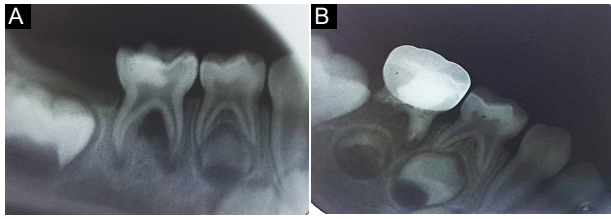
Lesion Sterilization and Tissue Repair Therapy for Primary Second Mandibular Molar. A: Radiographic examination shows a large area of radiolucency around the mesial root of the tooth; B: 12 months after treatment, although early root resorption in the second primary molar is visible, but radiographical sign of the underlying tooth bud indicates normal developing condition and first permanent molar is erupting normally.
